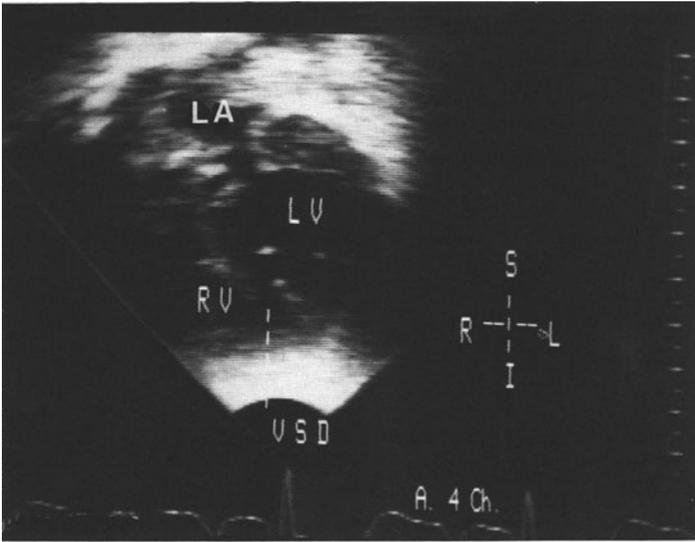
The top frame shows an apical four-chamber view of a patient with an apical muscular ventricular septal defect (*VSD*). (abbreviations are the same as in Figure 1). The bottom frame is the same as in the top panel, but after venous injection of contrast medium. A jet of contrast traversed the ventricular septal defect, demonstrating the right-to-left shunt.
